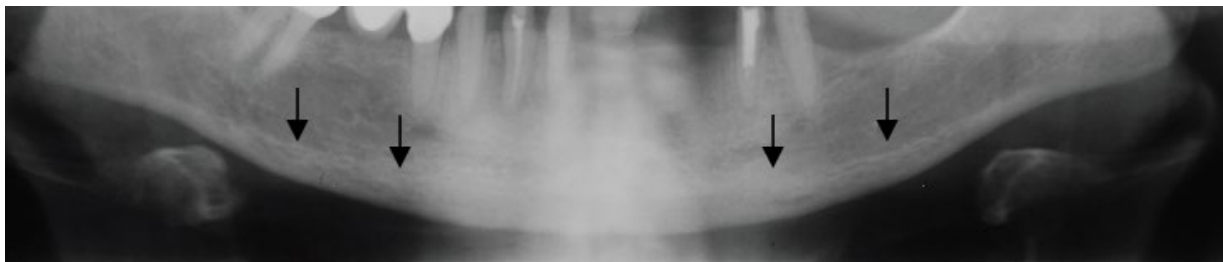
C2 type of mandibular cortical bone in MCI. Note the erosion on both sides of the mandibular cortex. The mandibular cortex looks more porous, thus producing a mixed density radiographic appearance of bone.¹¹
